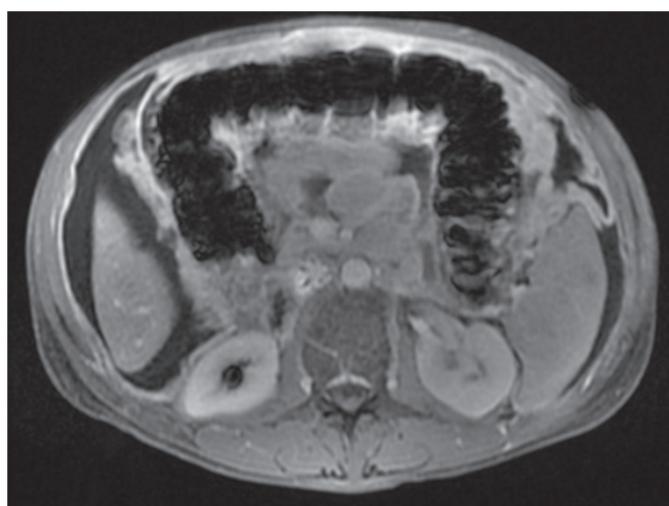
Peritoneal carcinomatosis is seen on axial MRI with peritoneal enhancement.
